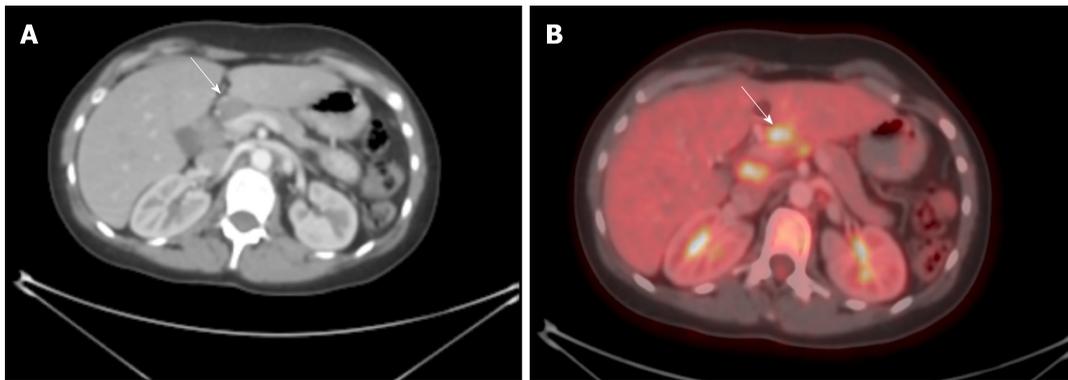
Abnormal FDG uptake on positron emission tomography. A: Computed tomography scan of the abdomen showing enlarged hepatic LN; B: Positron emission tomography showing abnormal FDG uptake in the same LN. FDG: Fluorodeoxyglucose; LN: Lymph node.
